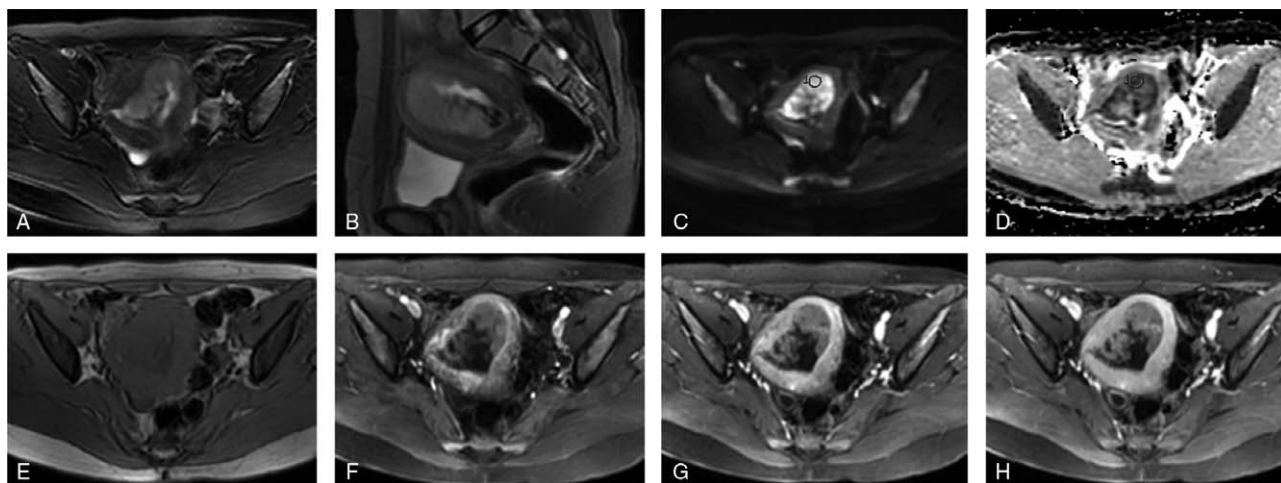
A 39-year-old woman with CS confirmed by surgery and pathology. (a, b) Axial and sagittal T2-weighted image indicated the mass was endometrioid in the uterine cavity. (c) Axial diffusion-weighted imaging showed hyperintensity in the solid component of tumor. (d) Axial ADC map revealed the solid component of CS showed restricted diffusion, and the mean ADC, minimum ADC, and rADC values were $0.78 \times 10^{-3} \text{mm}^2/\text{s}$, $0.55 \times 10^{-3} \text{mm}^2/\text{s}$, 0.58, respectively. (e) Axial T1-weighted image revealed the solid component of CS showed slight hypointensity. (f-h) Axial contrast-enhanced magnetic resonance imaging including arterial phase, venous phase, and delayed phase, and CS displayed mild and delayed enhancement. CS = carcinosarcoma, ADC = apparent diffusion coefficient, rADC = lesion-muscle ADC ratio.
